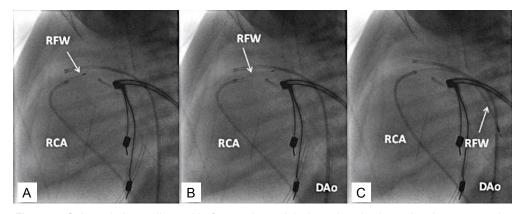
Selected cine-radiographic frames in straight lateral projections showing progressive advancement of the radiofrequency wire (RFW) (thin arrows) via a right coronary artery (RCA) catheter into the main pulmonary artery (A & B) and from there into the descending aorta (DAo) via the ductus arteriosus (not marked) (C).
